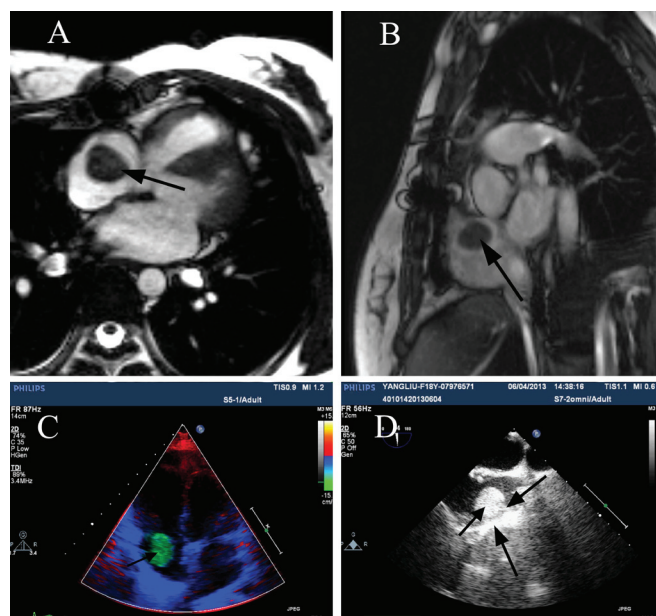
Imaging results demonstrating the mass in the right atrium: (A, B) magnetic resonance imaging; (C) transthoracic echocardiography; (D) transesophageal echocardiography.
